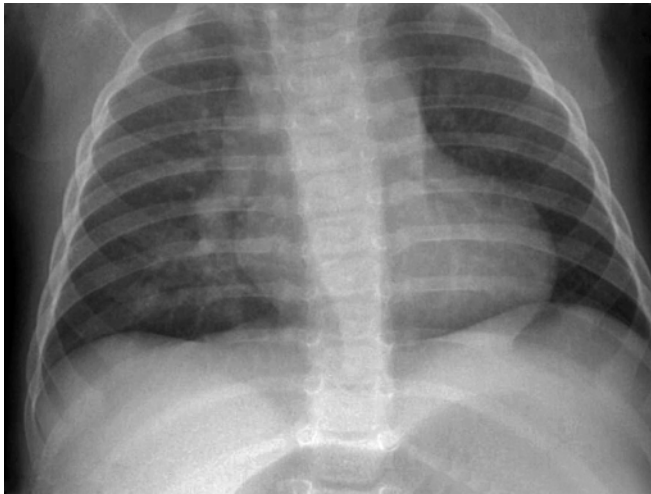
Chest X-ray, tetralogy of Fallot showing a “boot-shaped” heart with upturned apex and oligoemic lung fields
